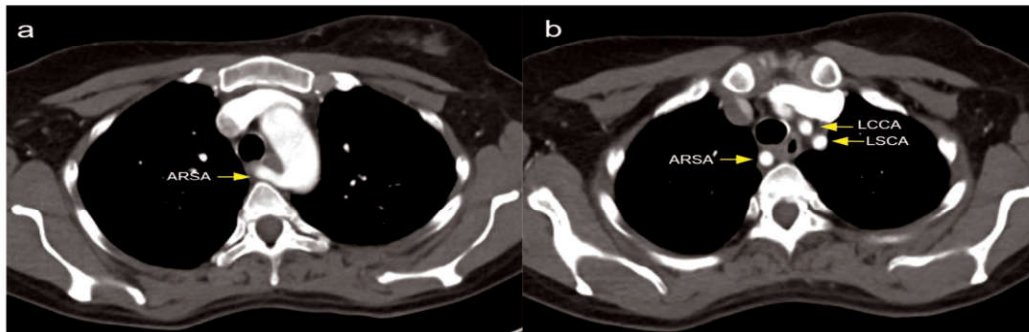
Axial CT chest contrast images showing aberrant right subclavian artery.
